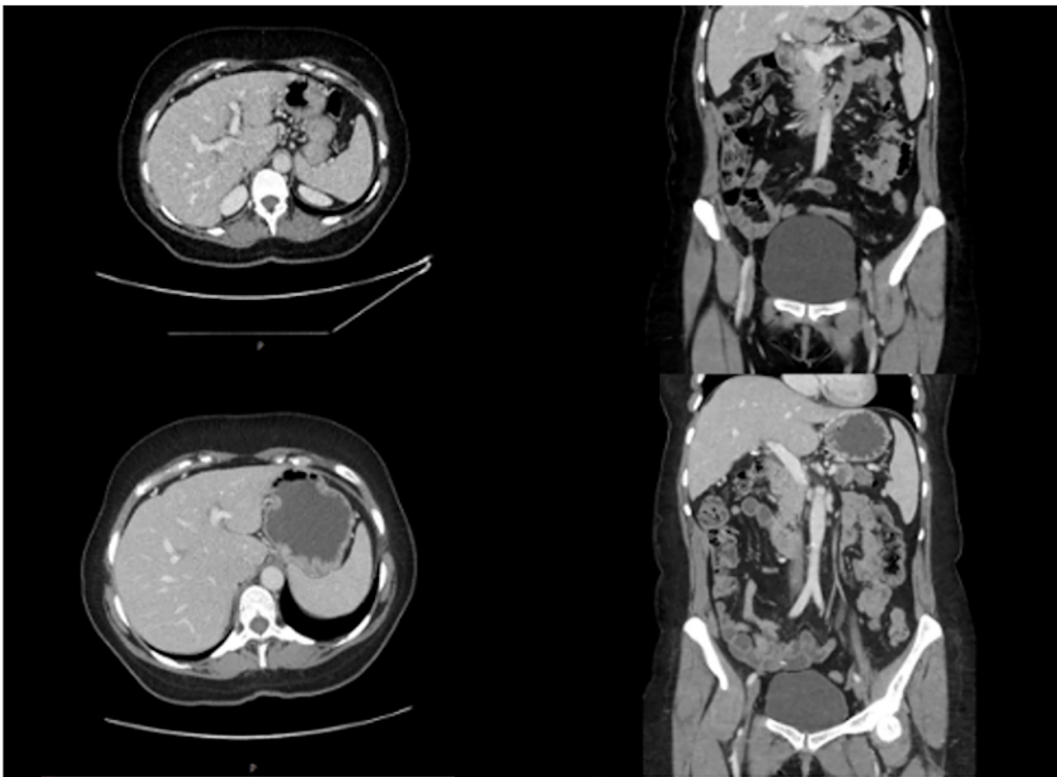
Durability of hepatic response on long-term surveillance imaging (2020). Top row: Contrast-enhanced CT performed in July 2020, with axial images (left) and coronal reconstructions (right), showing continued absence of detectable liver metastases. Bottom row: Interval contrast-enhanced CT performed in October 2020, with axial images (left) and coronal reconstructions (right), demonstrating sustained complete radiological response in the liver with no detectable metastatic disease.
